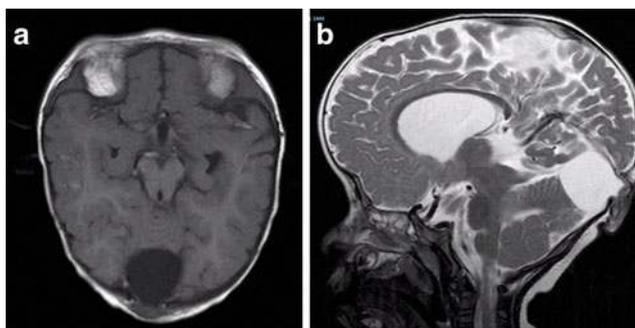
Patient with Apert syndrome with occipital encephalocele. a Axial T1-weighted MRI scan and b sagittal T2-weighted MRI scan demonstrating encephalocele
